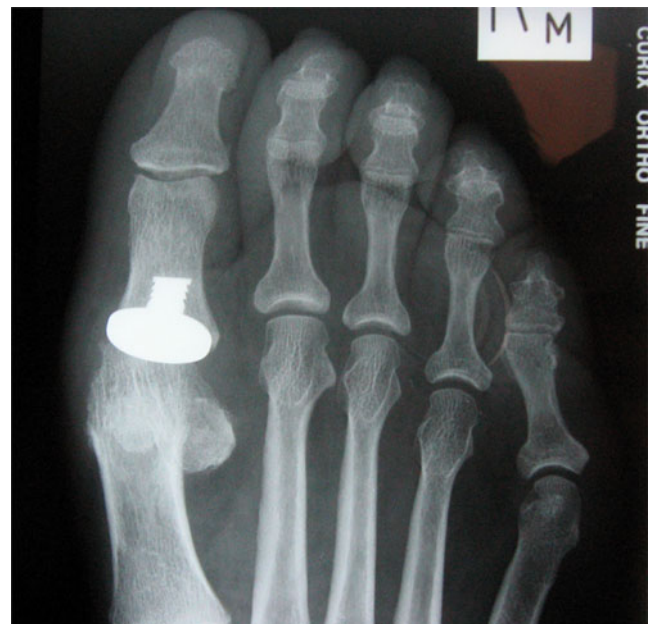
Postoperative anteroposterior (AP) radiograph of patient 12 months after a first metatarsophalangeal hemiarthroplasty
